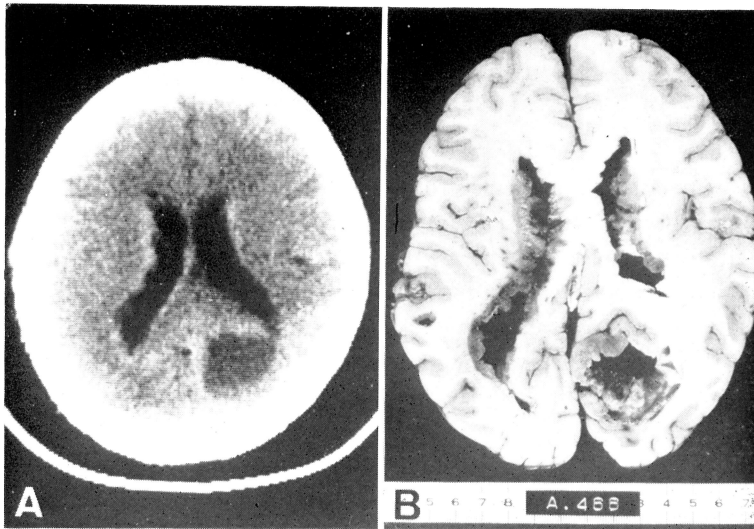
A : CT scan of the brain revealing a low-density area with ringed enhancement in the right occipital lobe. The wall of the lateral ventricles is showing a band-like enhancement. B : The horizontal cut surface of the brain sectioned according to the CT scan phase showing a metastatic lesion in the right occipital lobe, the inside of which is cystic. The wall of the lateral ventricles is infiltrated all over by tumorous mass.
